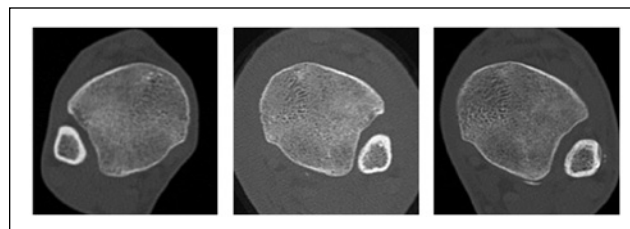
CT scans of a 24-year-old male with a Weber C ankle fracture treated with open reduction internal fixation of the lateral malleolus and one 4.5 mm quadricortical syndesmosis screw. Immediate postoperative CT scan (middle) shows posterior translation of the fibula with increased anterior fibular-incisura distance compared to the uninjured ankle (left). The postsyndesmosis screw removal CT (right) shows interval spontaneous reduction.
